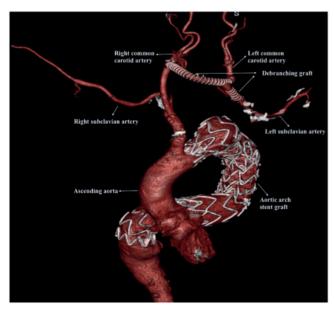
Follow-up computed tomography angiographic scan of the debranching procedure showing patent grafts without significant stenosis and a successfully treated aortic arch aneurysm.
